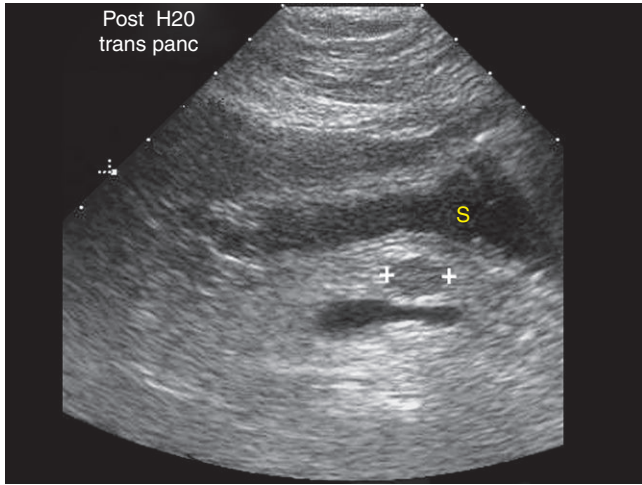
Transabdominal ultrasound performed after ingesting water shows the stomach (S) and a small hypoechoic mass (calipers) within the body of the pancreas.
